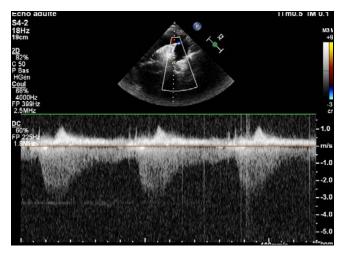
Continuous wave Doppler with a maximum gradient of 56 mmHg and diastolic prolongation flow, typical of aortic coarctation.
